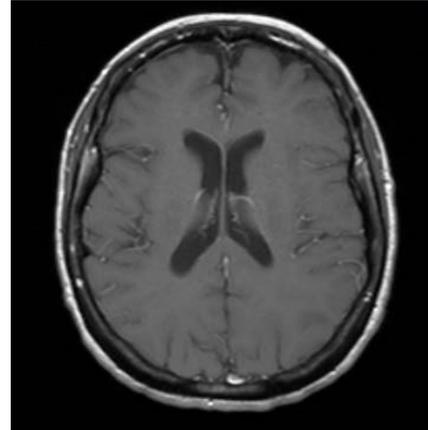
MRI head axial post contrast T1 sequence shows no enhancement of the white matter lesions.
